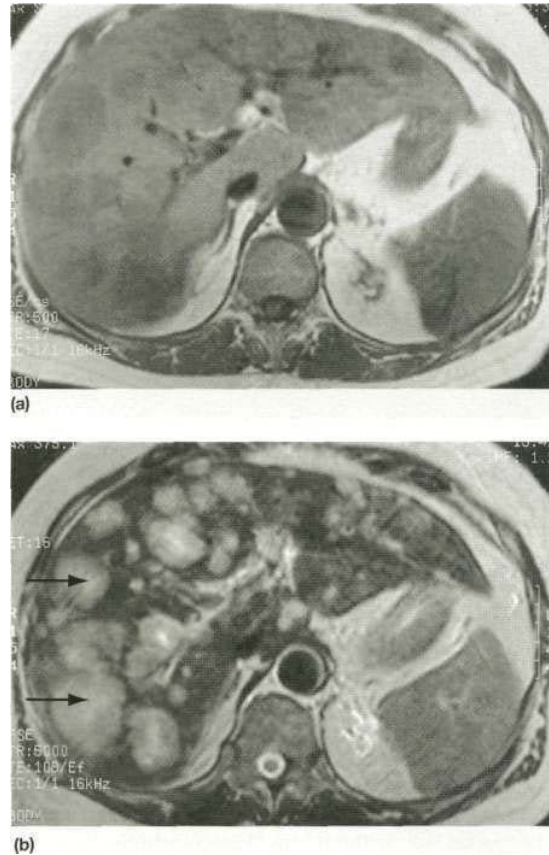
Liver MRI. (a) T1 - and (b) T2-weighted sequences showing multiple liver metastases. Structures of fluid density have high signal on T2 images. Note the central tumour necrosis in (b) (arrows).
